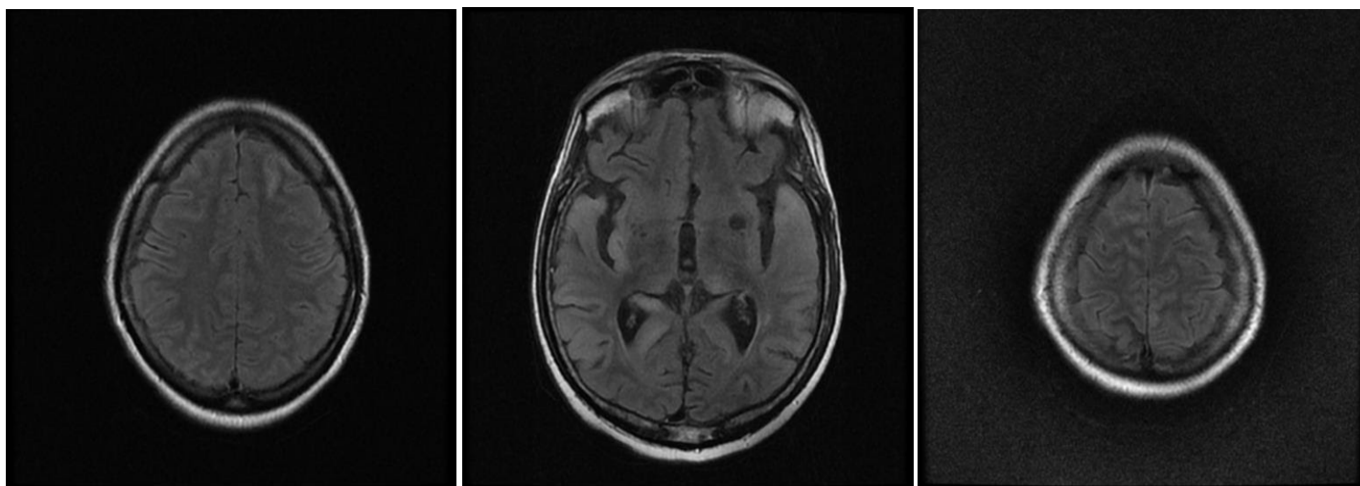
MRI of Brain on alternate day after admission
